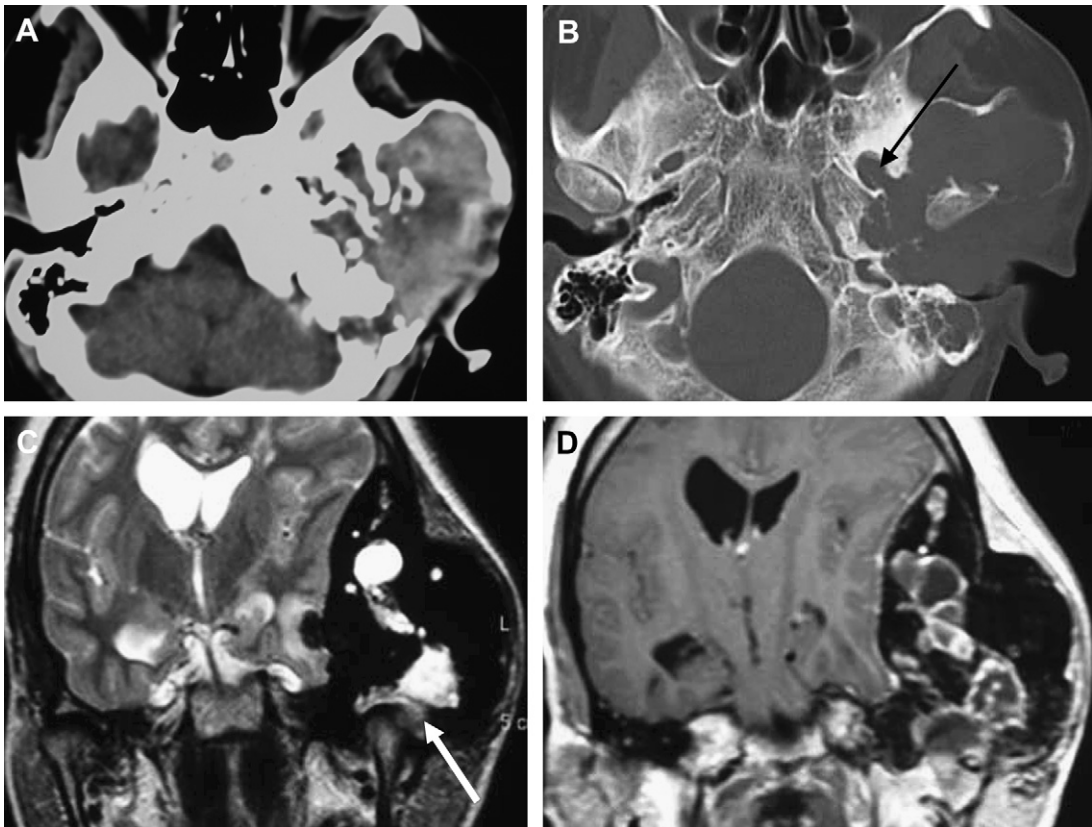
Axial CT images in soft tissue (A) and a bone window (B) show a large lytic lesion expanding the lateral aspect of the greater sphenoid wing, temporal bone, and glenoid cavity and involving the left TMJ. Extensive bone remodeling and thinning, with some areas of bony dehiscence and fine bony septa, are also shown. Note the bony dehiscence on the lateral margin of the foramen ovale (*black arrow*). Coronal T2-weighted (C) and postgadolinium T1-weighted (D) images show to advantage the craniocaudal extent of the lesion, the presence of multiple cysts, and joint effusion (*white arrow in C*). Also, note the dramatic mass effect upon the intracranial structures (chondroblastoma).
